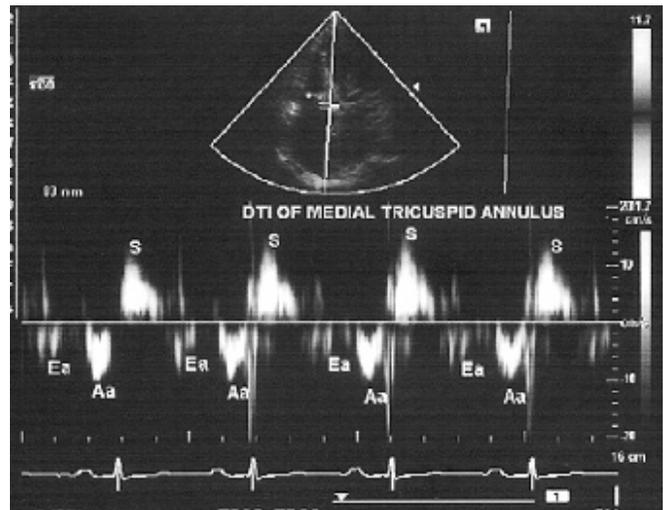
Tissue Doppler imaging from medial tricuspid annulus showing diminished Ea velocity and Aa velocity.
